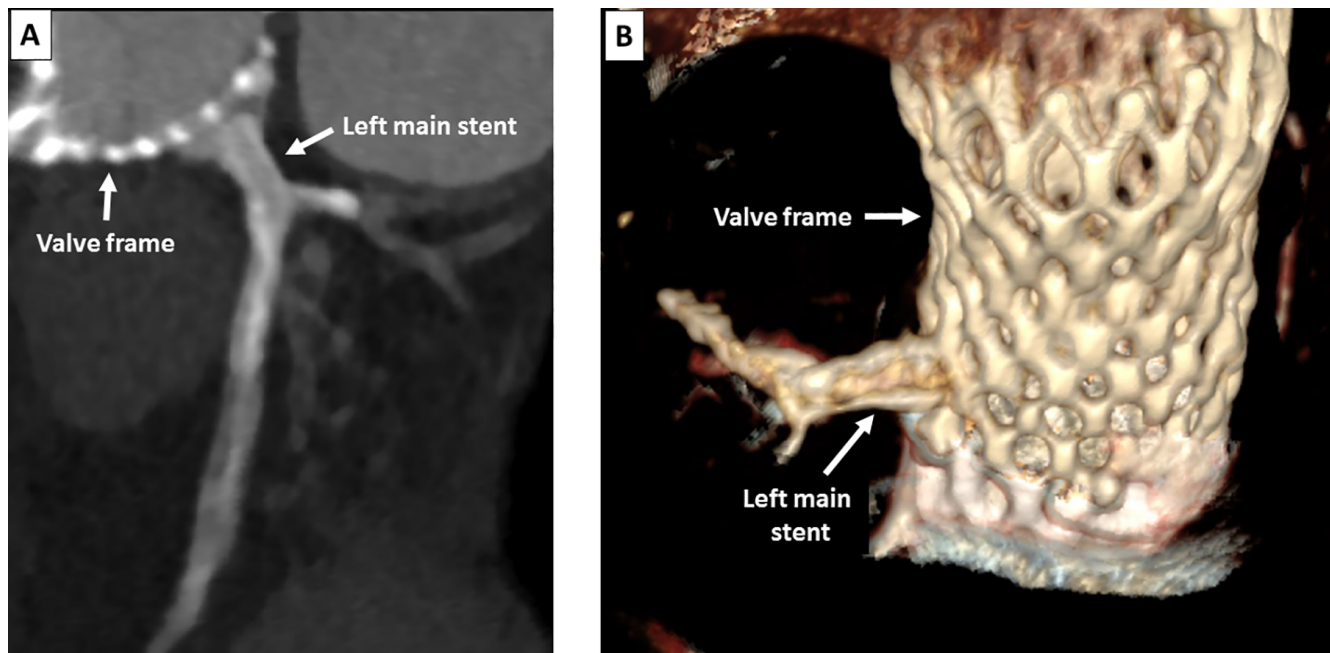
Post procedural computed tomography scan after 3 weeks showing widely patent LM stent protruding toward the valve frame (*Panel A*) together with three-dimensional reconstruction (*Panel B*).
